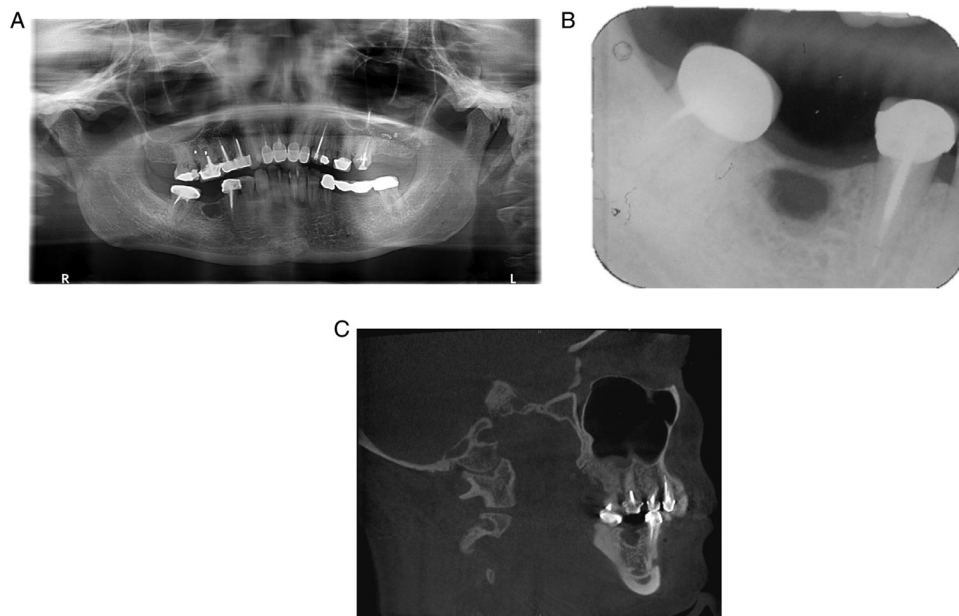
(A), (B) Panoramic and periapical radiography showing a well-circumscribed radiolucent lesion just below the crest of the alveolar bone of tooth 30. (C) Sagittal cone beam computed tomography section showing a well-defined corticated hypodensity in the posterior body of the mandible, right side.
